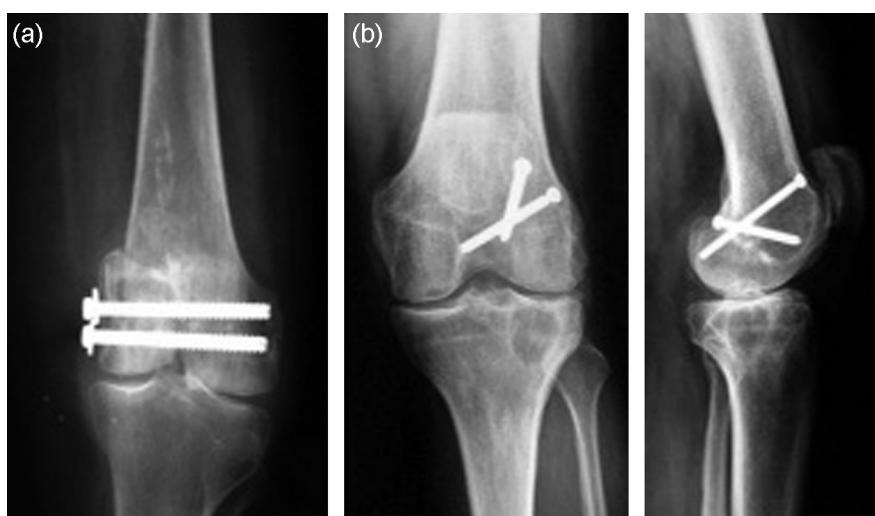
a: radiographs showing insufficient reduction on the post-operative antero-posterior view; b: after 10 years, the antero-posterior and lateral views show anatomic reduction.
